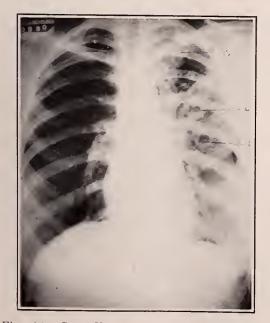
Case VIII. Roentgenogram of April 25, 1929, showing cavities (a), (b) and (c), with exudative densities through upper left lung field. Right lung field free from abnormal shadow.
